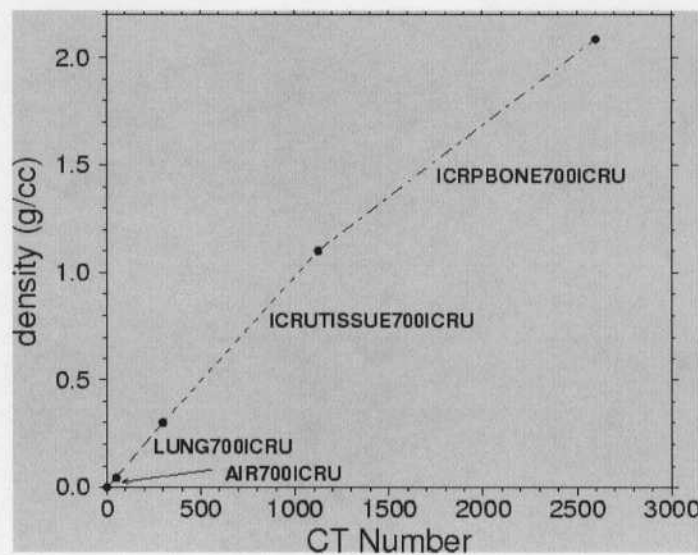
The default ramp for converting CT values to material and density in CTCreat [9]. (With permission from the National Research Council of Canada)
